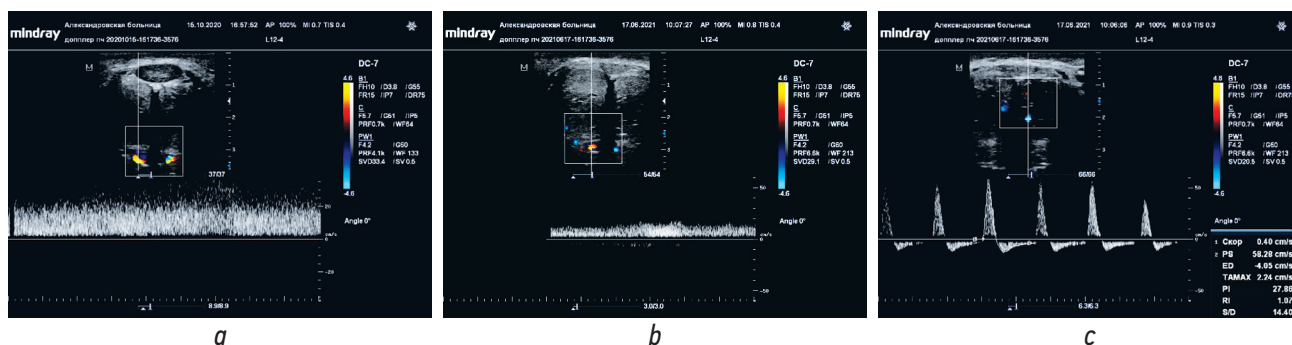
Doppler ultrasound of the vessels of the penis of patient E., 66 years old, BPH and venogenic erectile dysfunction. *a* – Before surgery: in the tumescence phase V_{max} 37.7 cm/s, *RI* 0.65; IIEF-5 before surgery 14 points, Valsalva’s test is positive, the dorsal cavernous vein did not collapse and the blood flow through it was 20.5 ml/min; *b* – after bipolar enucleation of the prostate (TUEB): in the tumescence phase V_{max} 41.1 cm/s, the discharge of blood through the dorsal cavernous vein decreased to 11.4 ml/min; *c* – after bipolar enucleation of the prostate: in the erection phase V_{max} 58 cm/s, *RI* 1.07; IIEF-5 after surgery 20 points
